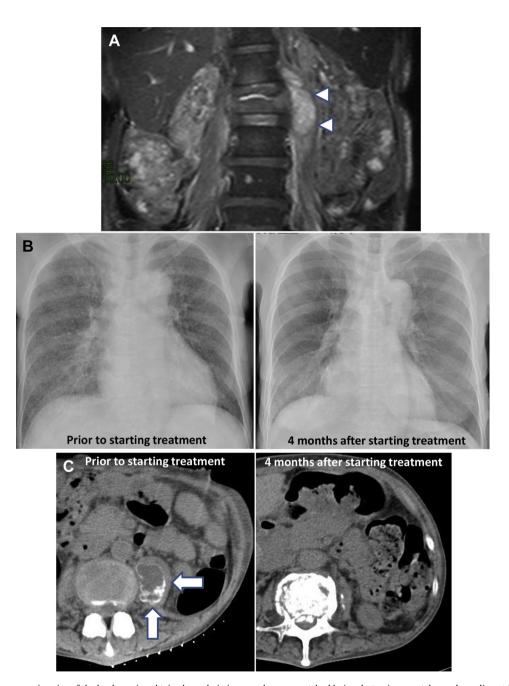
(A) Magnetic resonance imaging of the lumbar spine obtained on admission reveals a paravertebral lesion destroying a vertebra and an adjacent left iliopsoas lesion (arrowheads). (B) Chest roentgenogram on admission shows bilateral miliary shadows. (C) On lumbar spinal computed tomography (CT), the iliopsoas lesion appears as a low-density area with an outer layer of egg-shell calcification (arrows). Follow-up spinal CT images (C) indicate a decrease in size of the low-density area, suggesting an abscess. Pulmonary miliary shadows are improved on the chest roentgenogram (B) approximately 4 months after initiating antituberculosis therapy.
